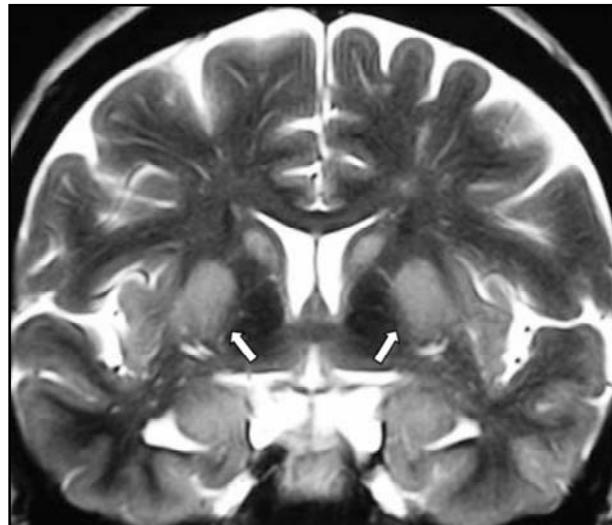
Brain MRI: The coronal "FLAIR" image shows bilateral symmetric hyperintense lesions in the basal ganglia, temporal lobe and hippocampal formation. (Observation: the arrows are showing the lesions.)
